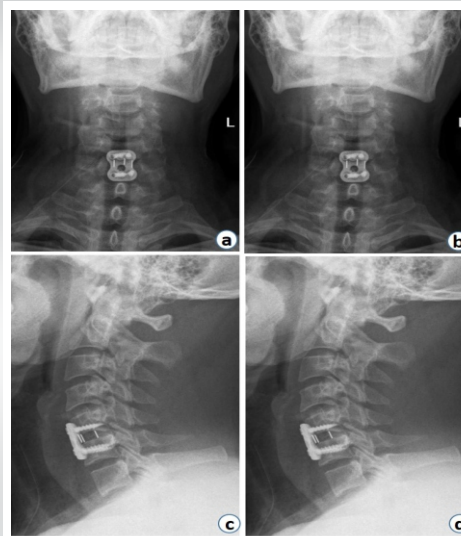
Post Post-operative X-rays: AP (a) and Lateral view (b) show well -aligned cervical spine with implant in-situ.
